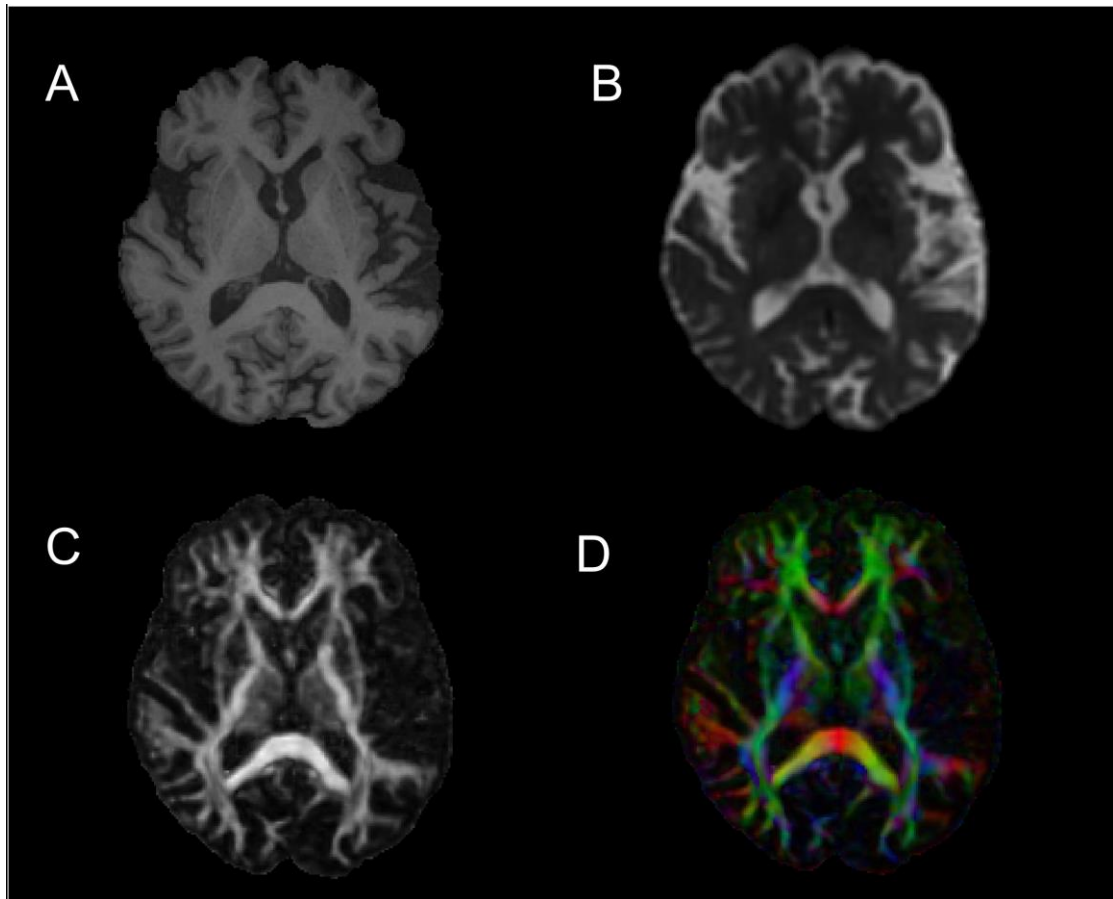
T1, DWI, FA and FA colour coded images of a single slice axial view of a representative subject.
